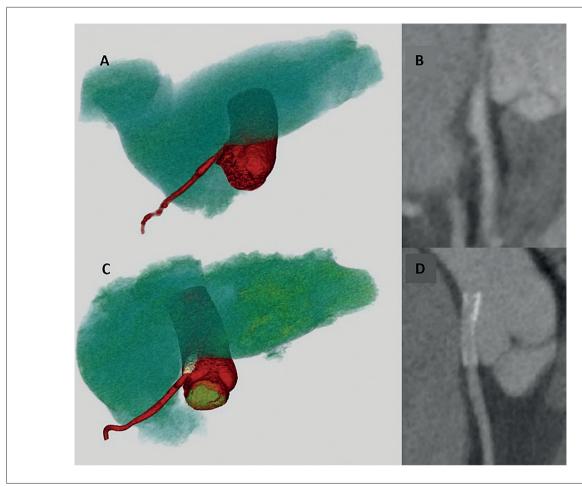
Coronary computed tomography angiography (patient 4) before and after angioplasty of left main coronary artery (LMCA) with stent implantation. In the upper row (A and B), pre-angioplasty images show significant luminal narrowing at LMCA origin due to extrinsic compression by the main pulmonary artery. In the lower row (C and D), post-angioplasty images demonstrate the stent covering the LMCA from the ostium, with preserved lumen and no signs of residual stenosis. Images were obtained using three-dimensional reconstruction (A and C) and curved reconstruction (B and D).
